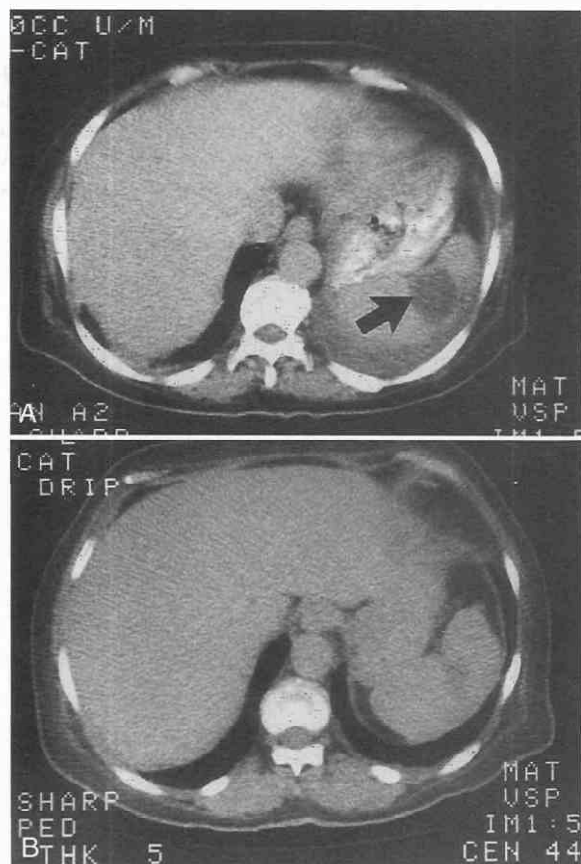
Tuberculosis. A, CT scan shows a low-density area (arrow) in the spleen, believed to be early changes of tuberculosis. B, A follow-up scan shows resolution of the area several months after the institution of antituberculous therapy.
